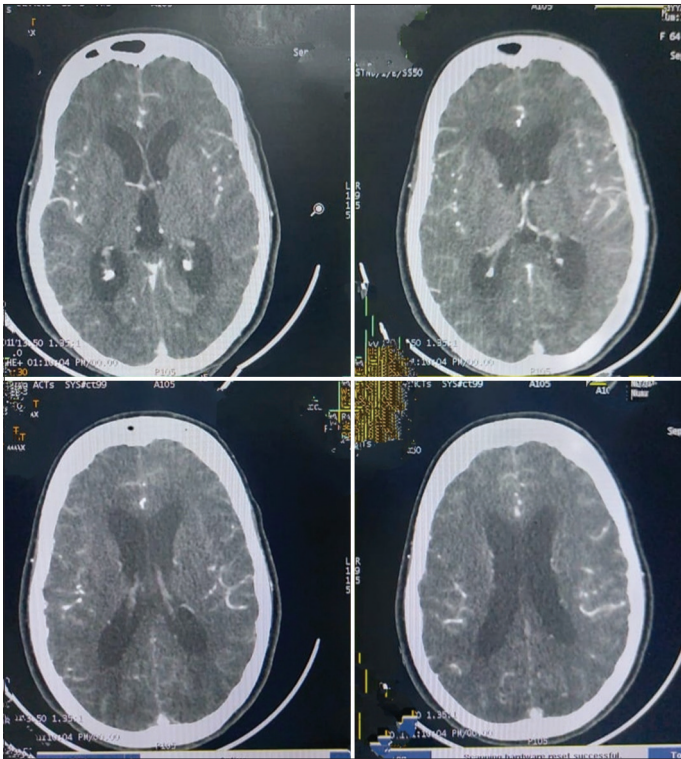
Computed tomography brain showing subarachnoid hemorrhage (case 1)
